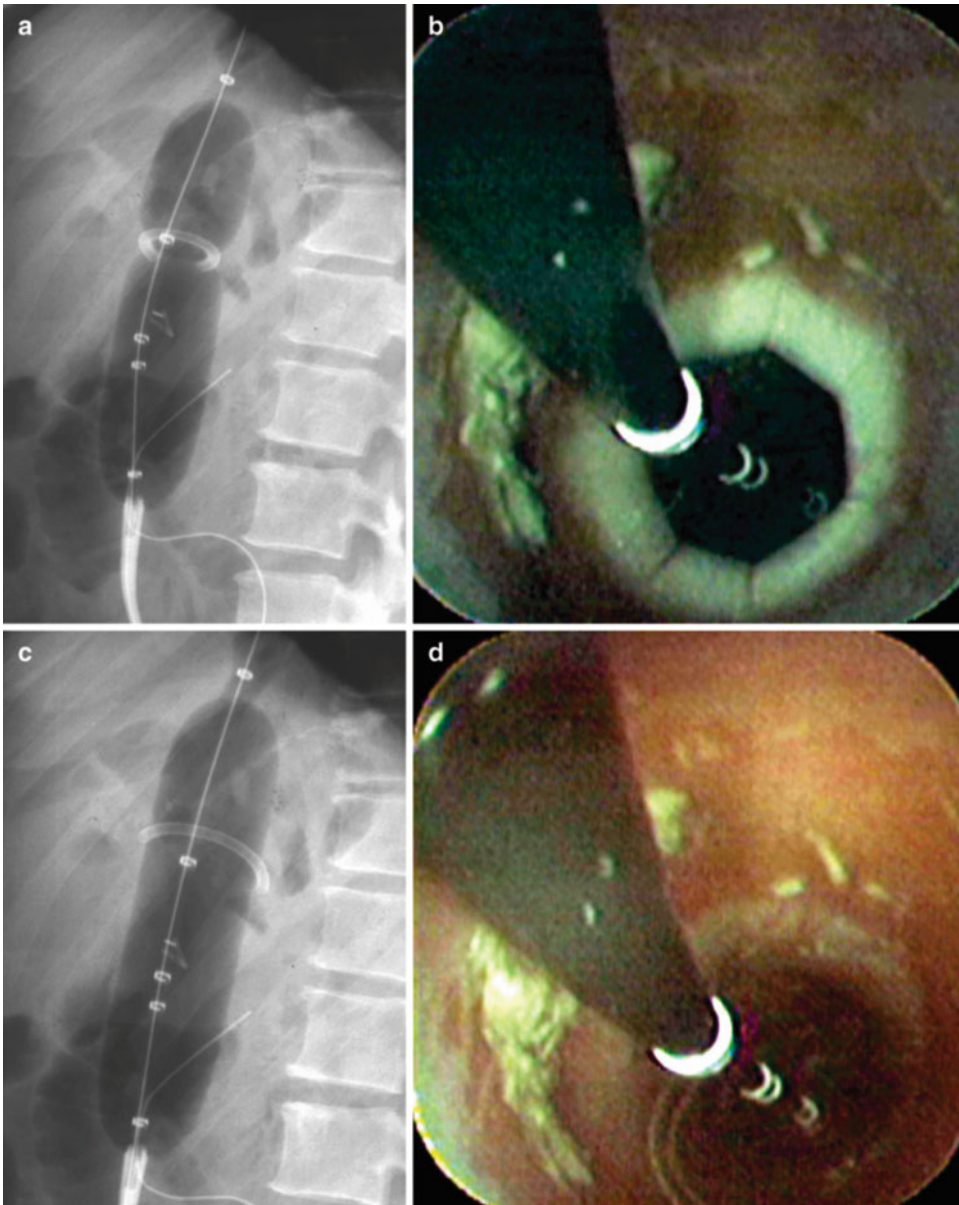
(a) X-ray; (b) endoscopic image of gastric pouch evidencing the inflated Rigiflex[®] balloon revealing the ring compression; (c) X-ray; (d) endoscopic image evidencing ring rupture after few minutes of dilation
